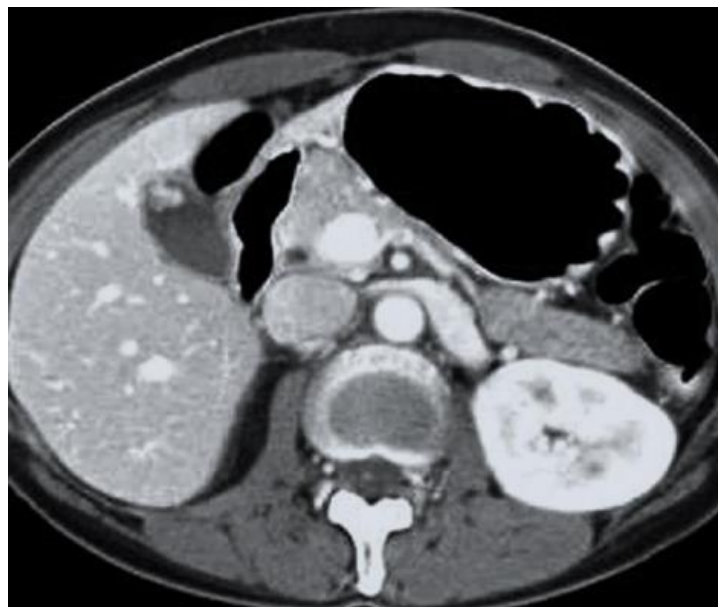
CT image demonstrating a well-defined, enhancing polypoidal mass arising from and adherent to the anterior wall of the gallbladder lumen, suggestive of a gallbladder polyp.
